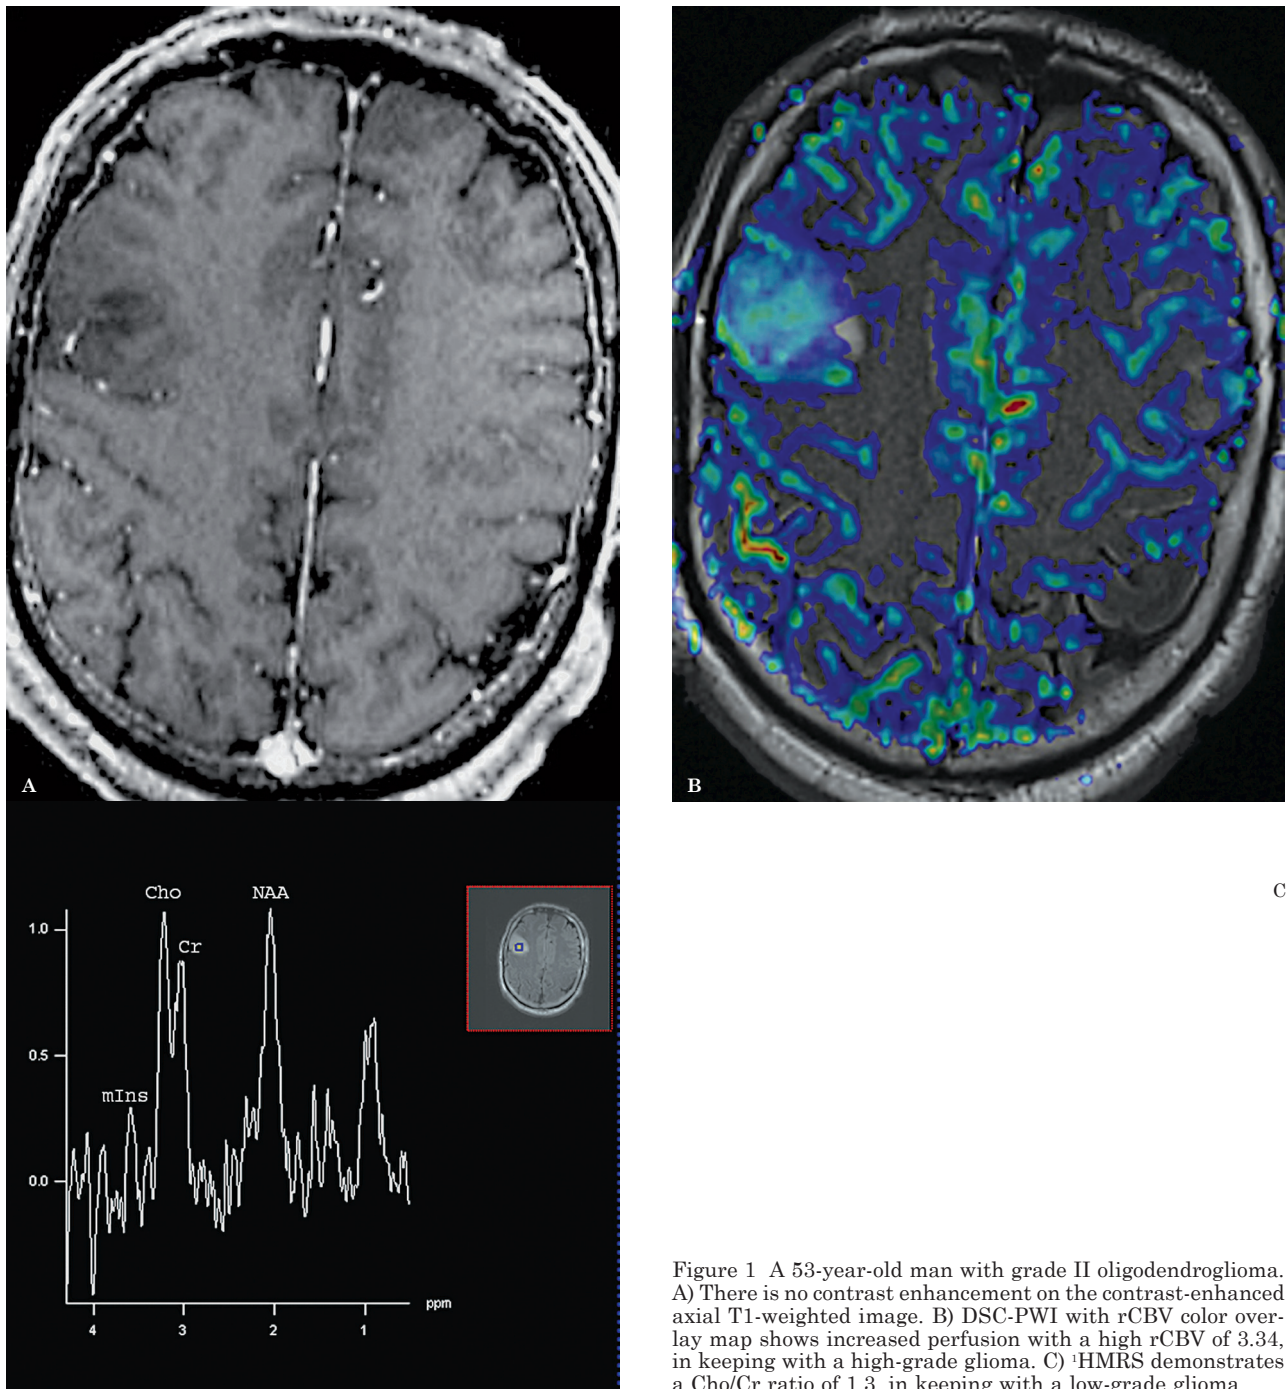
A 53-year-old man with grade II oligodendroglioma. A) There is no contrast enhancement on the contrast-enhanced axial T1-weighted image. B) DSC-PWI with rCBV color overlay map shows increased perfusion with a high rCBV of 3.34, in keeping with a high-grade glioma. C) ¹H MRS demonstrates a Cho/Cr ratio of 1.3, in keeping with a low-grade glioma.
